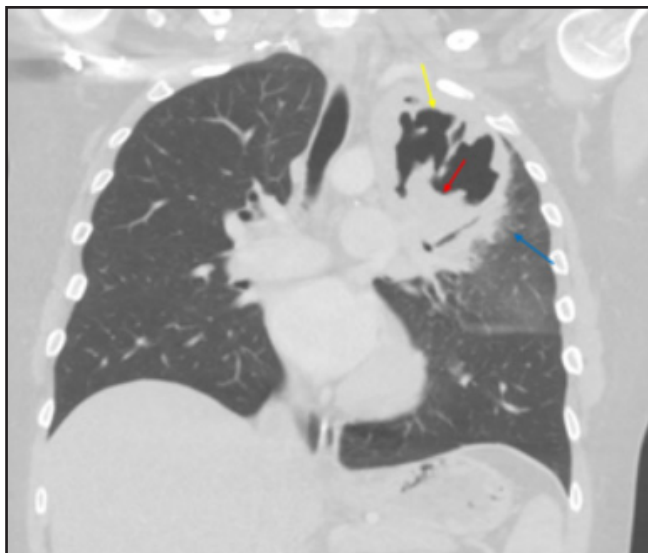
Granulomatosis with polyangiitis. Coronal contrast-enhanced CT in a patient with history of granulomatosis with polyangiitis demonstrating a thick-walled cavitary lesion (yellow arrow) with internal soft-tissue density representing superimposed aspergillosis (red arrow) and surrounding ground-glass hemorrhage (blue arrow).
